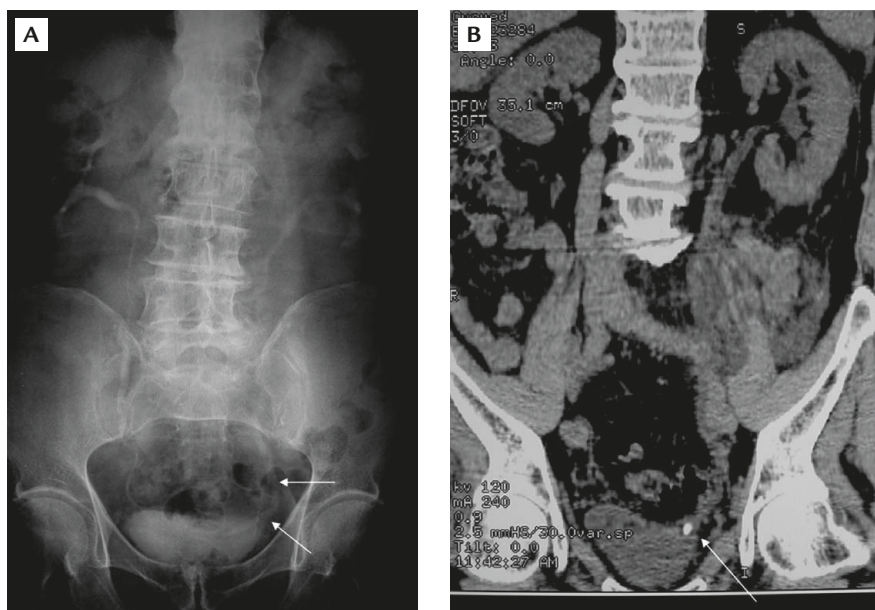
An 80-year-old male patient with left acute renal colic. (A) Intravenous urography shows mild dilatation of the left ureter (arrows) of unknown cause. (B) Unenhanced computed tomography with curved multiplanar reformatted reconstruction shows a small stone at the left ureterovesicle junction (arrow).
